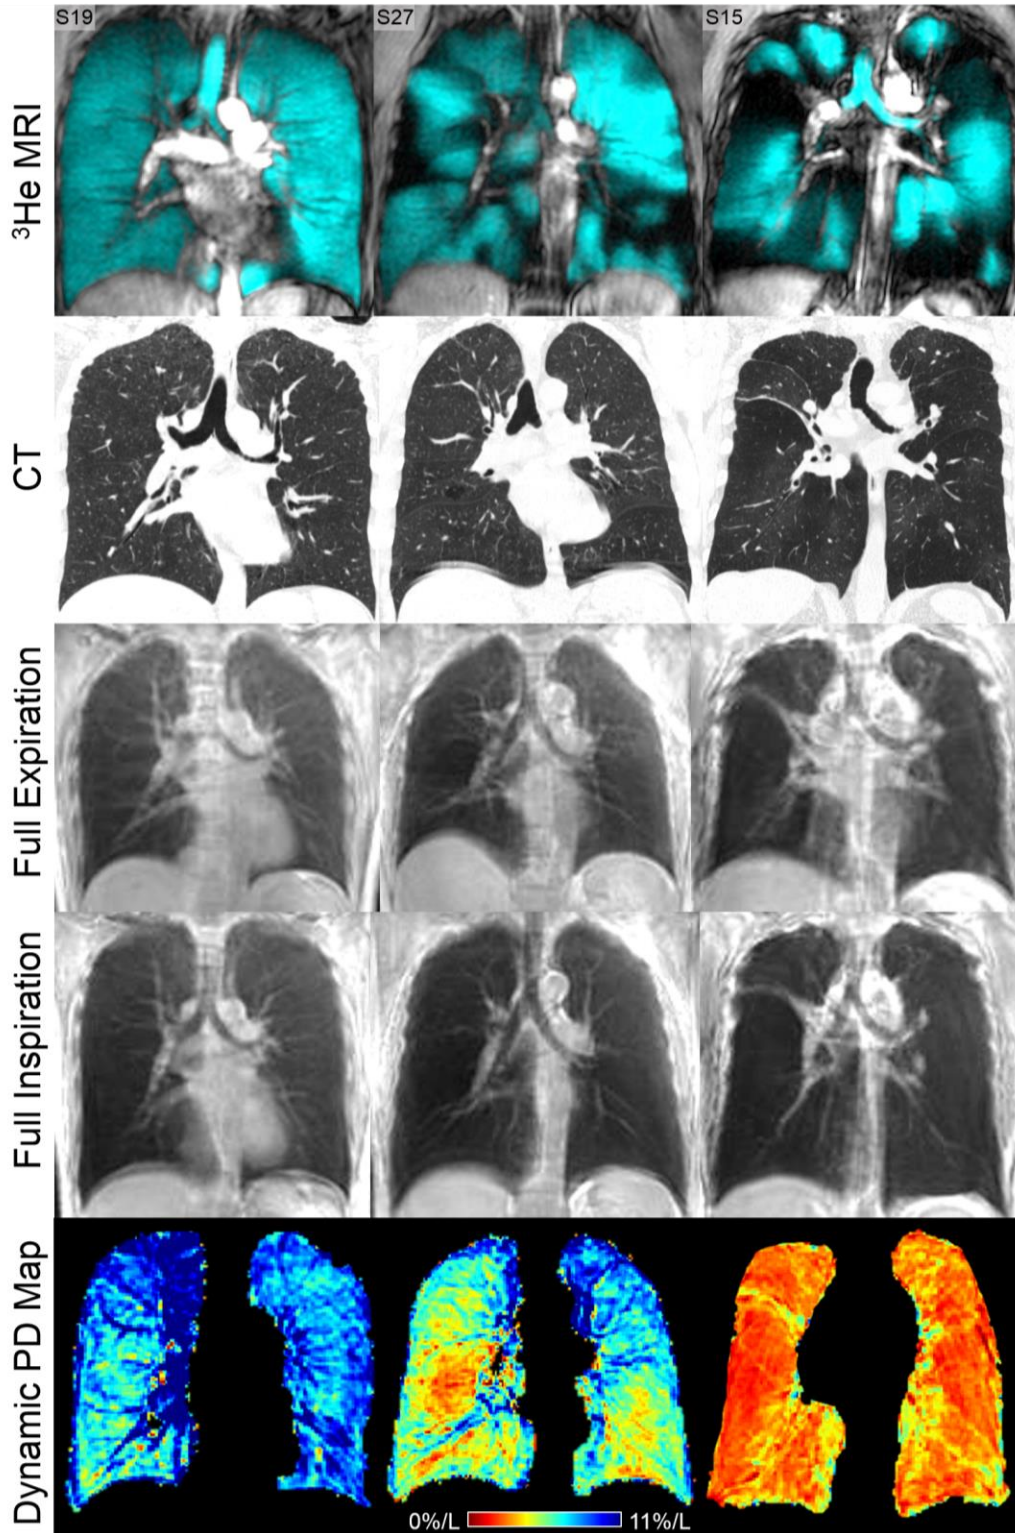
UTE MRI for Healthy Volunteers and Asthmatics
